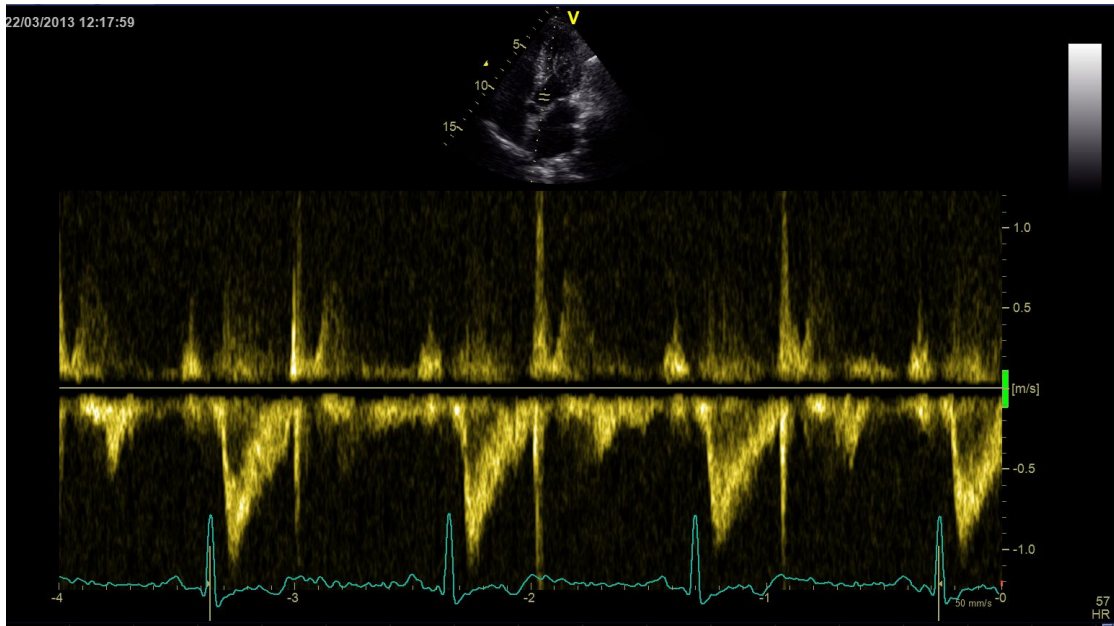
Pulsed Wave Doppler with region of interest superimposed on a b-mode image - bloodflow data from the left ventricular outflowtract
